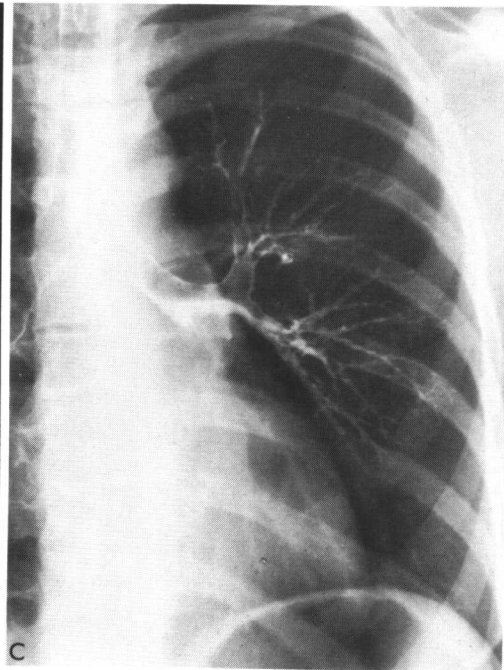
Bronchial Adenoma (Carcinoid Type). Views of the right hemithorax from posteroanterior (A) and lateral (B) roentgenograms demonstrate a roughly triangular shadow of homogeneous density occupying the superomedial portion of the right lung; the inferolateral border of the shadow is formed by the upward displaced minor fissure (arrow in A) and the posterior border by the anteriorly displaced major fissure (arrow in B). This shadow represents combined consolidation and atelectasis of the right upper lobe due to an endobronchial obstructing lesion (obstructive pneumonitis). A right bronchogram (C) reveals a smooth, rounded mass protruding into the right main-stem bronchus at the point of origin of the upper lobe bronchus; such an intraluminal filling defect is characteristic of bronchial adenoma. The lobe was resected; pathologic proof.
